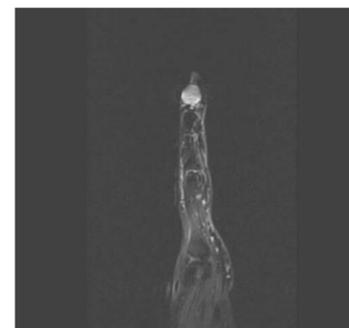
MRI sagittal T2 fat sat image showing cortical disruption and soft tissue mass.
